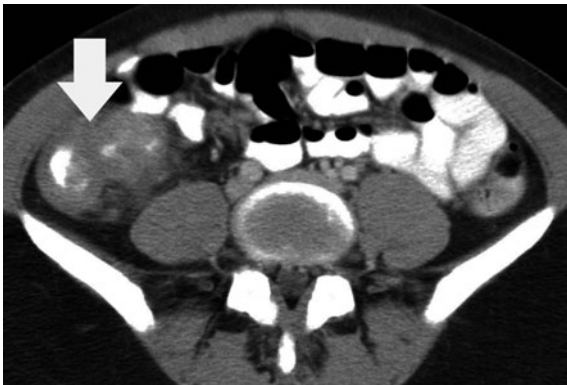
Inflammatory bowel disease in a 14-year-old-female with abdominal pain for two weeks. Axial contrast-enhanced CT image demonstrates extensive thickening and enhancement of the ileocecal region (*arrow*). The appendix, likely included in the phlegmon, could not be visualized
